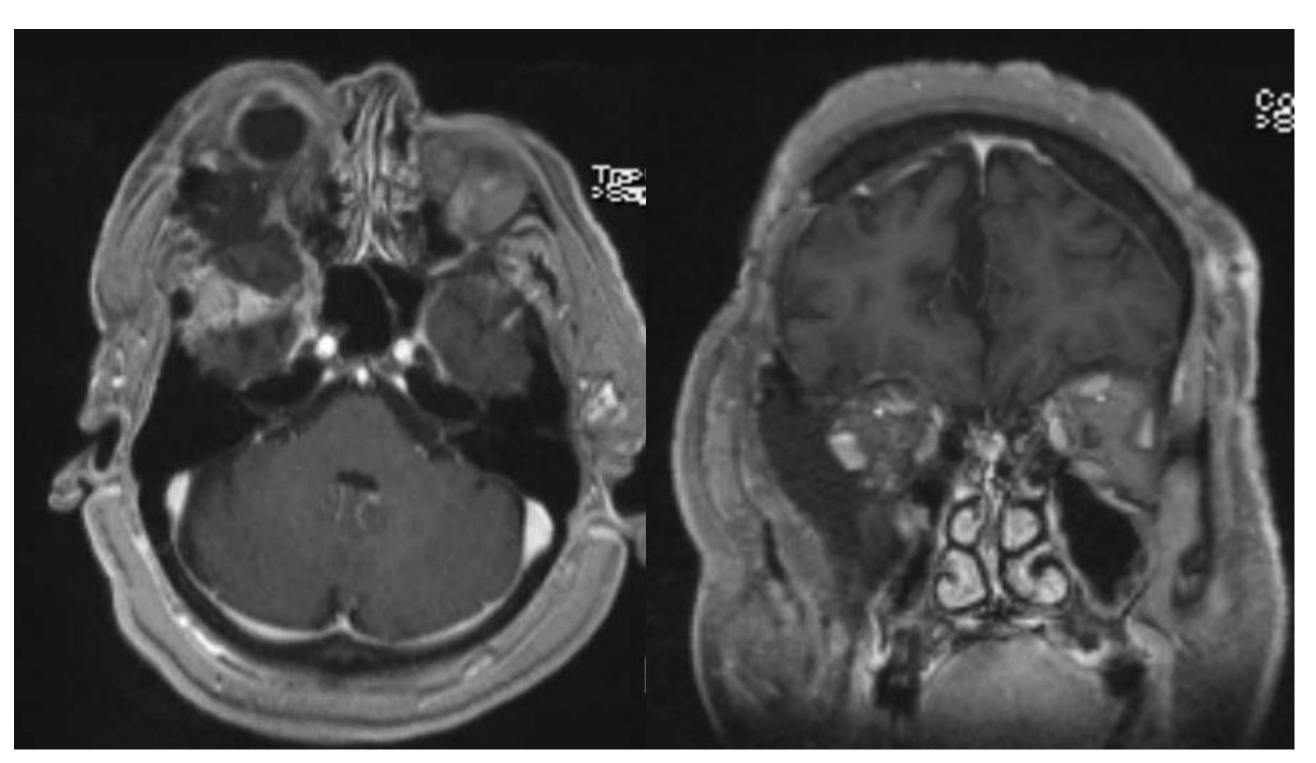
Postoperative MRI T1 with contrast axial (left) and coronal (right) images demonstrating near total resection of orbital and infraorbital components of the tumor with small residual along the posterior middle fossa skull base
